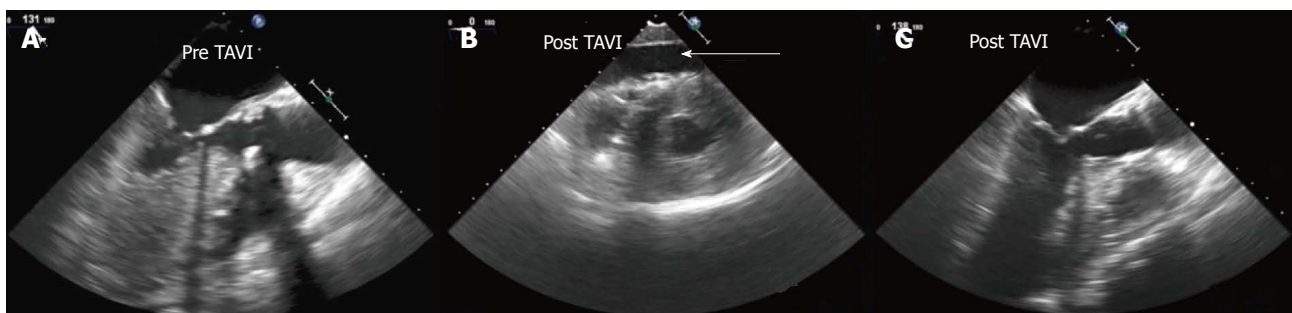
Aortic root rupture and cardiac tamponade (Case 2). A: Aortic valve assessment before TAVI, TEE mid esophageal long axis view; B: Aortic valve assessment after TAVI, TEE transgastric mid-ventricular short axis. Severe pericardial effusion is evidenced (arrow); C: Aortic valve assessment after TAVI, TEE mid esophageal long axis view. No signs of aortic root hematoma were observed in this case. TAVI: Transcatheter aortic valve implantation; TEE: Trans-esophageal echocardiography.
